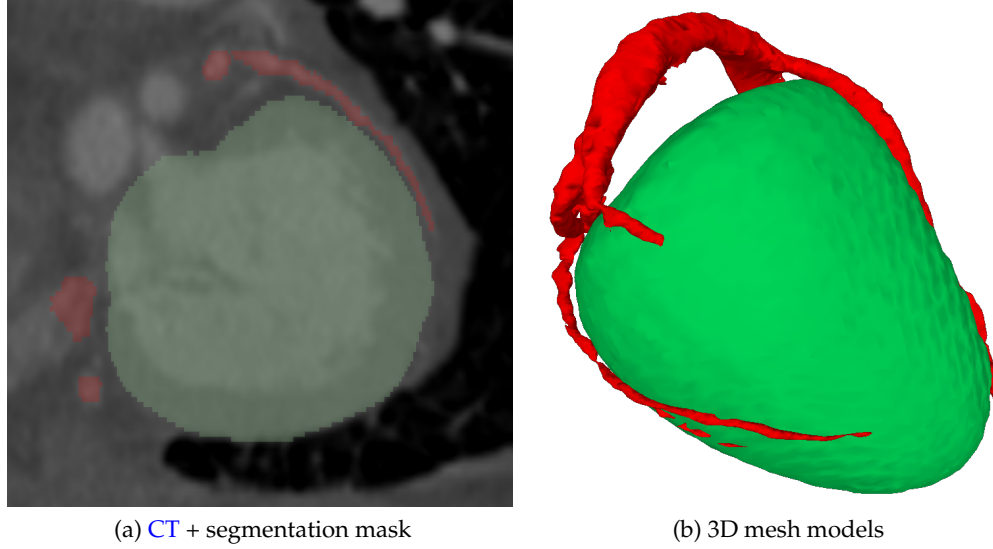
Segmented CTA dataset. (a) LV epicardial mask (green) with coronary vein mask (red). (b) LV epicardial mesh (green) with the coronary vein mesh (red).
